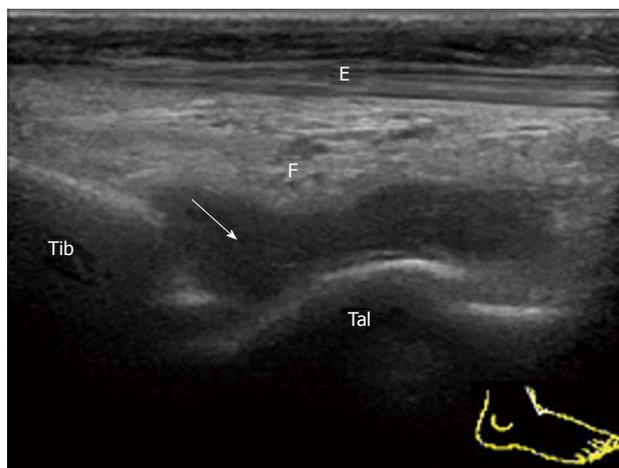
Severe tibiotalar joint synovitis in rheumatoid arthritis. Sagittal grey-scale sonogram of the anterior recess of the tibiotalar joint shows that a normal hyperechoic anterior fat pad (F) is displaced anteriorly by hypoechoic synovium (arrow). Tib: Tibia; Tal: Talus; F: Fat pad; E: Extensor hallucis longus.
